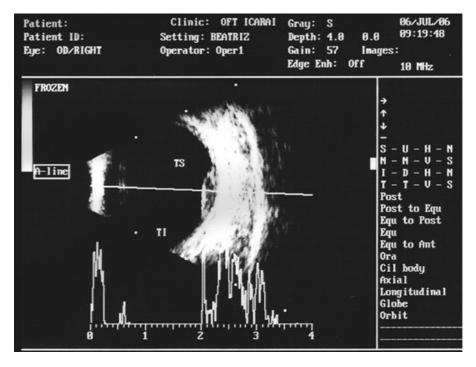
Same patient as in Figs. 13.1 and 13.3. A- and B-scan ultrasound shows an irregular internal reflectivity and no internal vascularity. No extensive serous retinal
